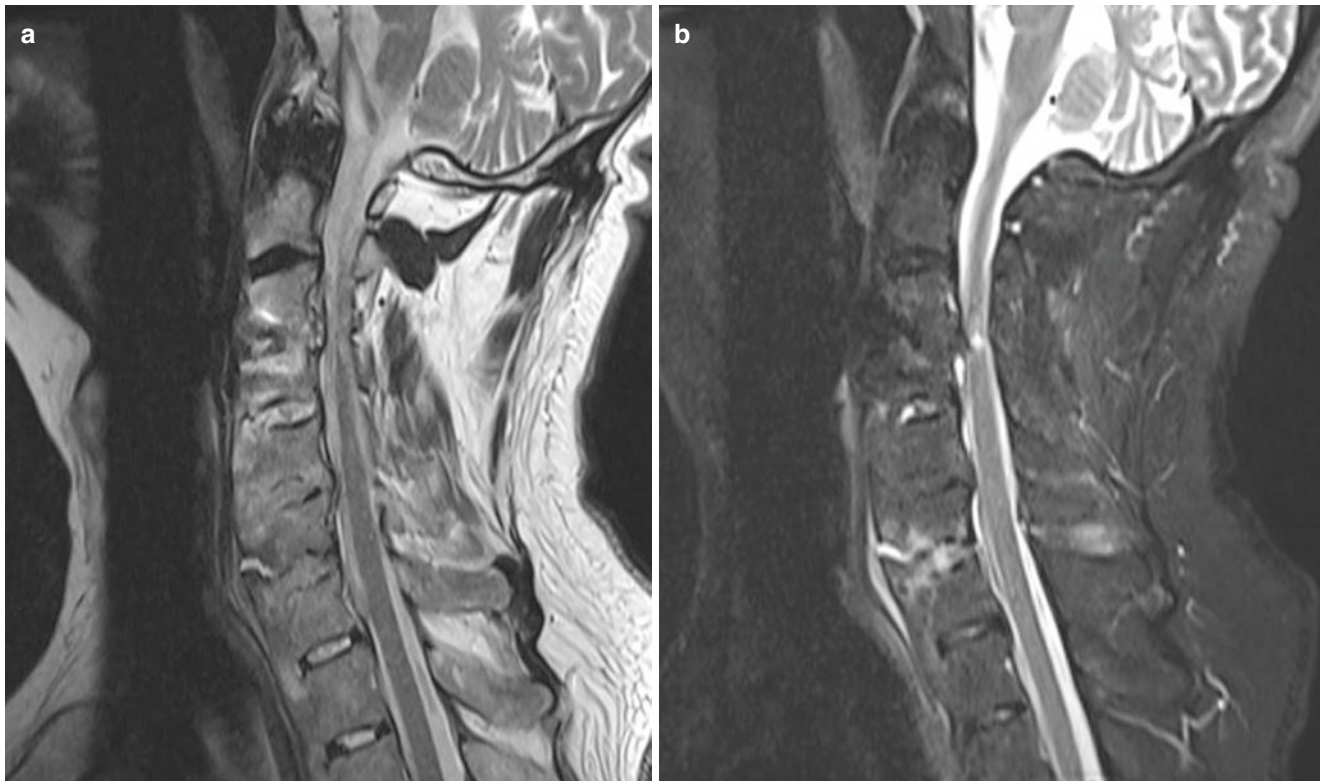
(a) Sagittal T2-weighted MR image of cervical spine demonstrating multiple levels of bone fusion by AS from C3 to C6 with ossification demonstrated as low signal at disc space and spinal stenosis at C3–C4. (b) STIR sagittal MR image demonstrating myelopathy at
